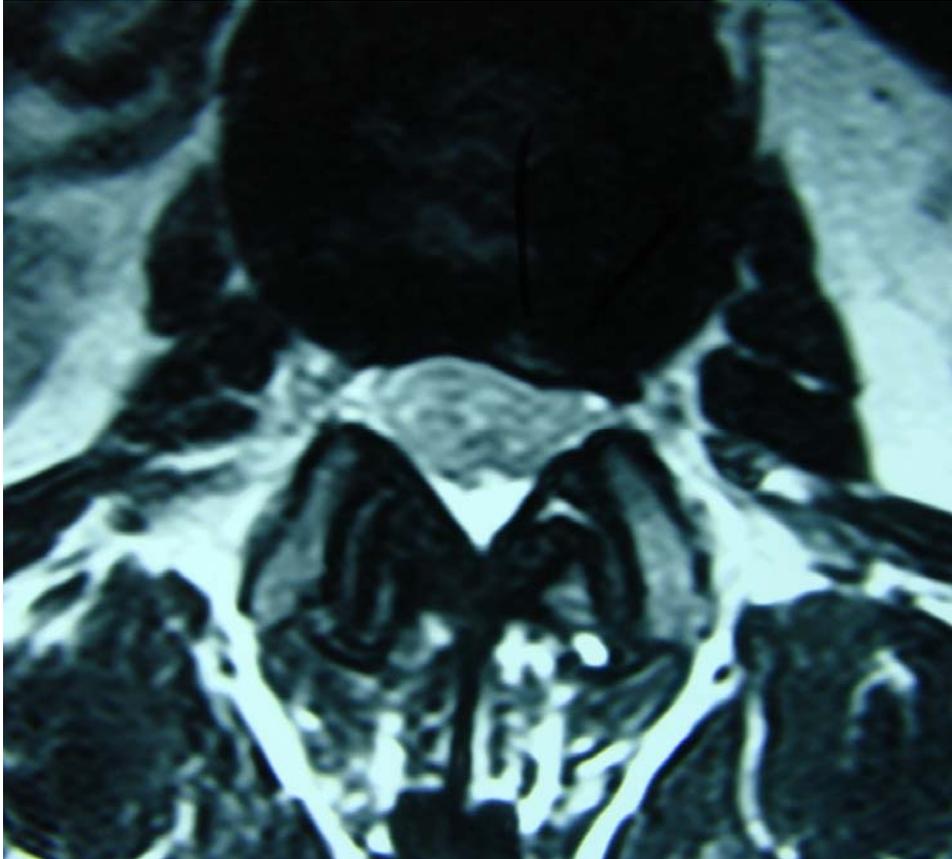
This is the post treatment axial MRI study of the L1-L2 left subligamentous and lateral recess disc herniation. The reading radiologist states that the moderate to large disc herniation originally seen in figure 4 is now smaller in this MRI taken post treatment. The radiologist did not know of our treatment. Compare figure 13 to figure 4 taken prior to flexion distraction adjusting.
